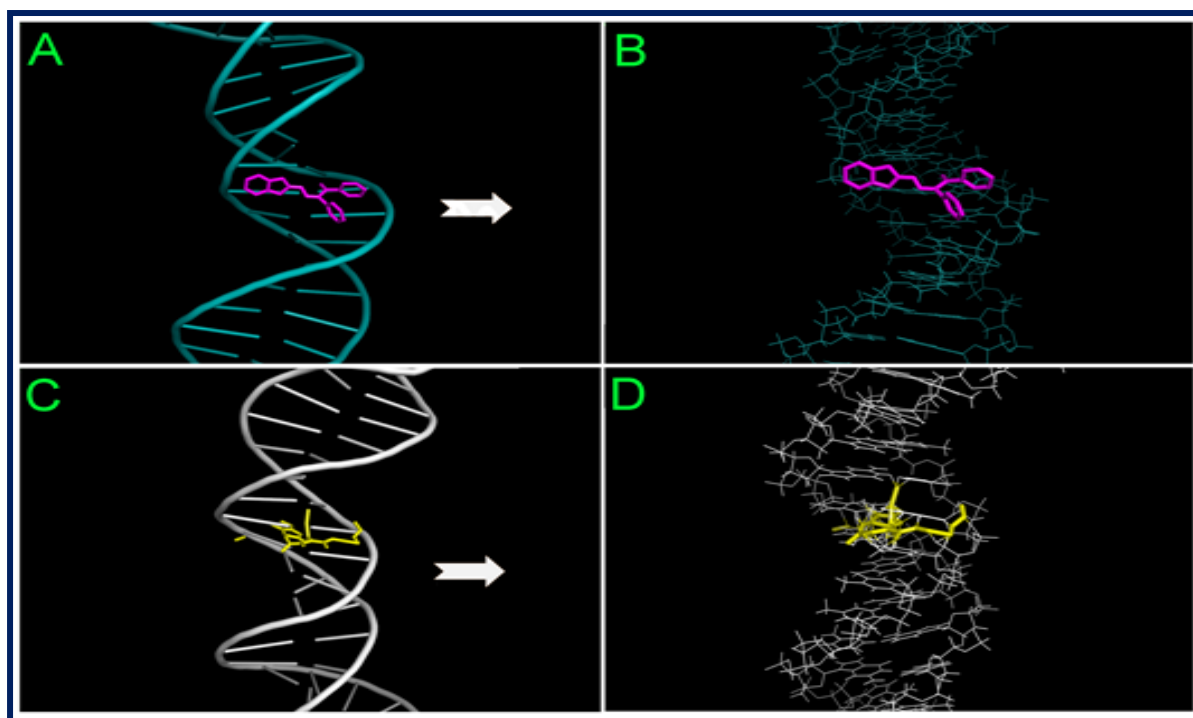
Stereo-view of the docked conformation of LH (A and B) and 1 (C and D) with CT DNA.
